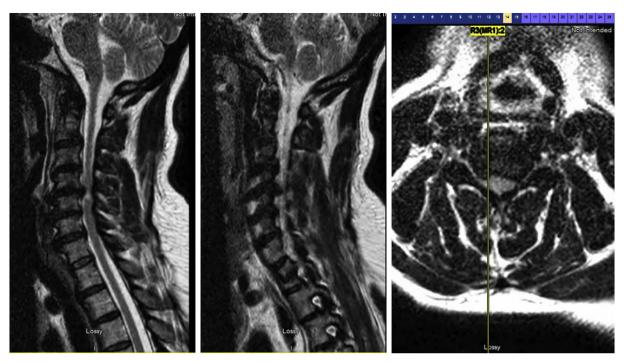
Cervical spine MRI at presentation demonstrating C4-C5 herniated nucleus pulposus.
